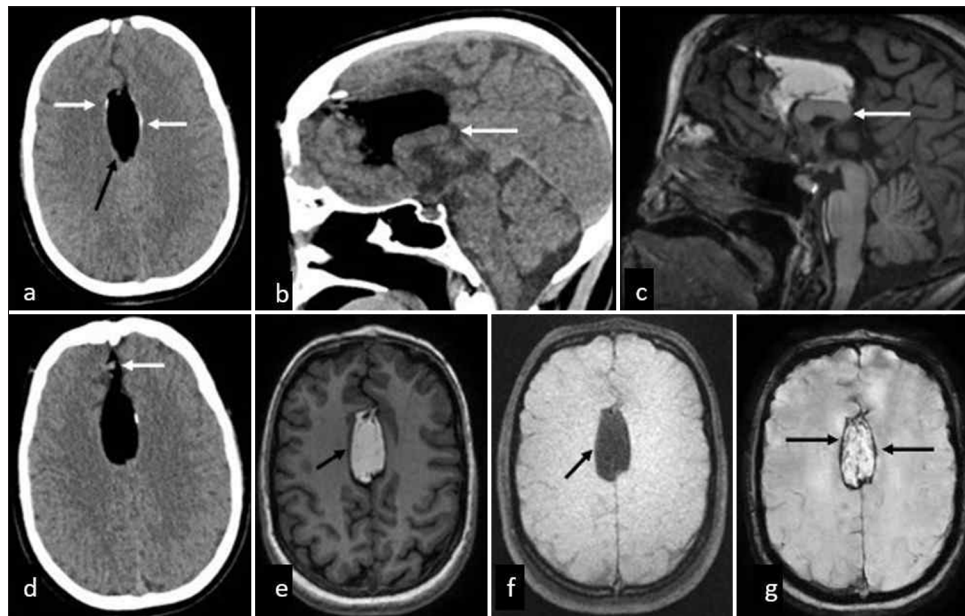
Lipoma of corpus callosum. (a) CT axial section of the brain shows well-defined fat density in the midline (black arrow) with evidence of bracket calcification (white arrows). (b,c) CT and MRI sagittal sections demonstrate partial agenesis of corpus callosum with absent distal body and splenium (white arrow). (d) CT axial section reveals extension of fat-density into the right para-midline sulcal space of the right frontal lobe (white arrow). (e,f) MRI axial sections reveal midline homogeneously hyperintense lesion on T1W image showing fat suppression, suggestive of tubulonodular corpus callosum lipoma. (g) Blooming artifacts on susceptibility weighted image noted along the periphery of the lesion (black arrows) mimicking hemorrhage, characteristic of an intracranial fat-containing lesion.
